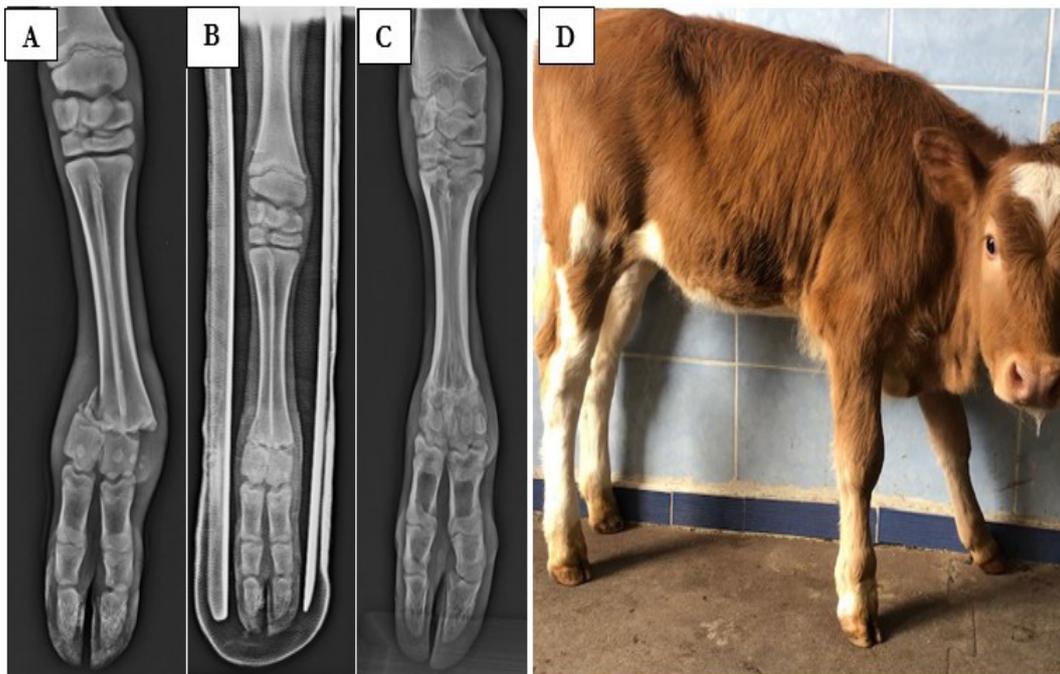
Treatment stages of a distal epiphyseal Salther Harris Type II fracture of a case A: Radiographic image of the fracture before treatment B: Radiograph of the fracture on day 0 after bandage with double PVC reinforced fiberglass plaster C: Radiograph of the fracture on day 35 after treatment D: Post-treatment of the calf 90 days clinical picture
